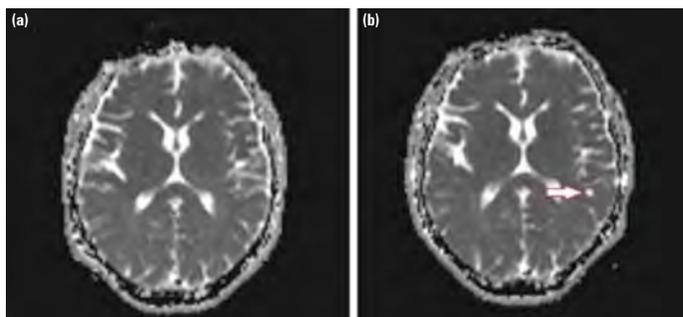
(a) Preoperative and (b) postoperative diffusion weight magnetic resonance imaging scans of the brain. Mark the new microischemic lesion that was detected at the ipsilateral parietal lobe.
